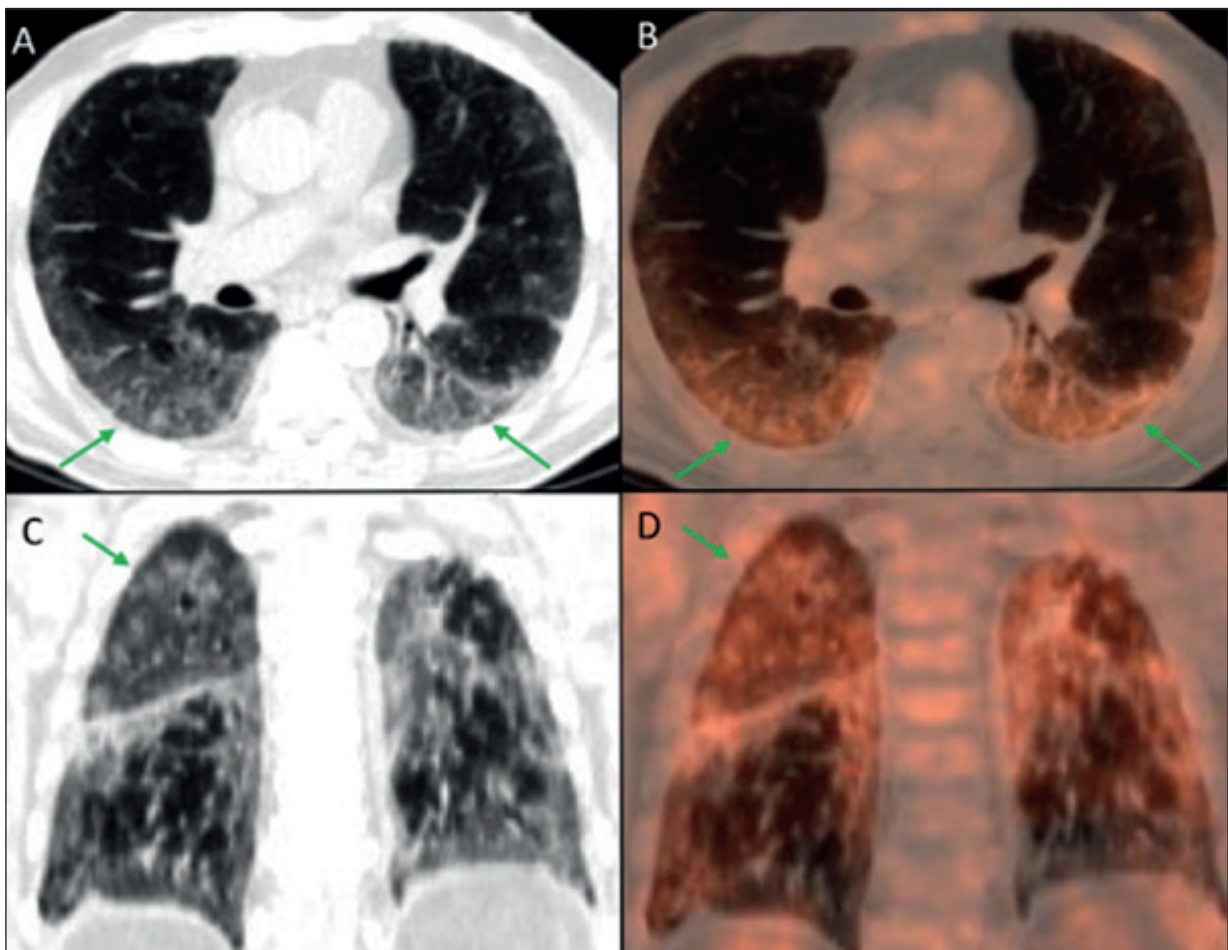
Incidental finding in a 73-year-old multiple myeloma patient who underwent [^{18}F]FDG-PET/CT for staging. Interstitial pneumonia (green arrows), characterized by bilateral ground glass opacities with peripheral distribution, was detected on co-registered CT (A, axial and C, coronal reconstructions), and classified as nM4-IF, suspicious for COVID-19 infection. This finding showed mild and non-specific increased [^{18}F]FDG-uptake on (B) axial and (D) coronal fused PET/CT image.
